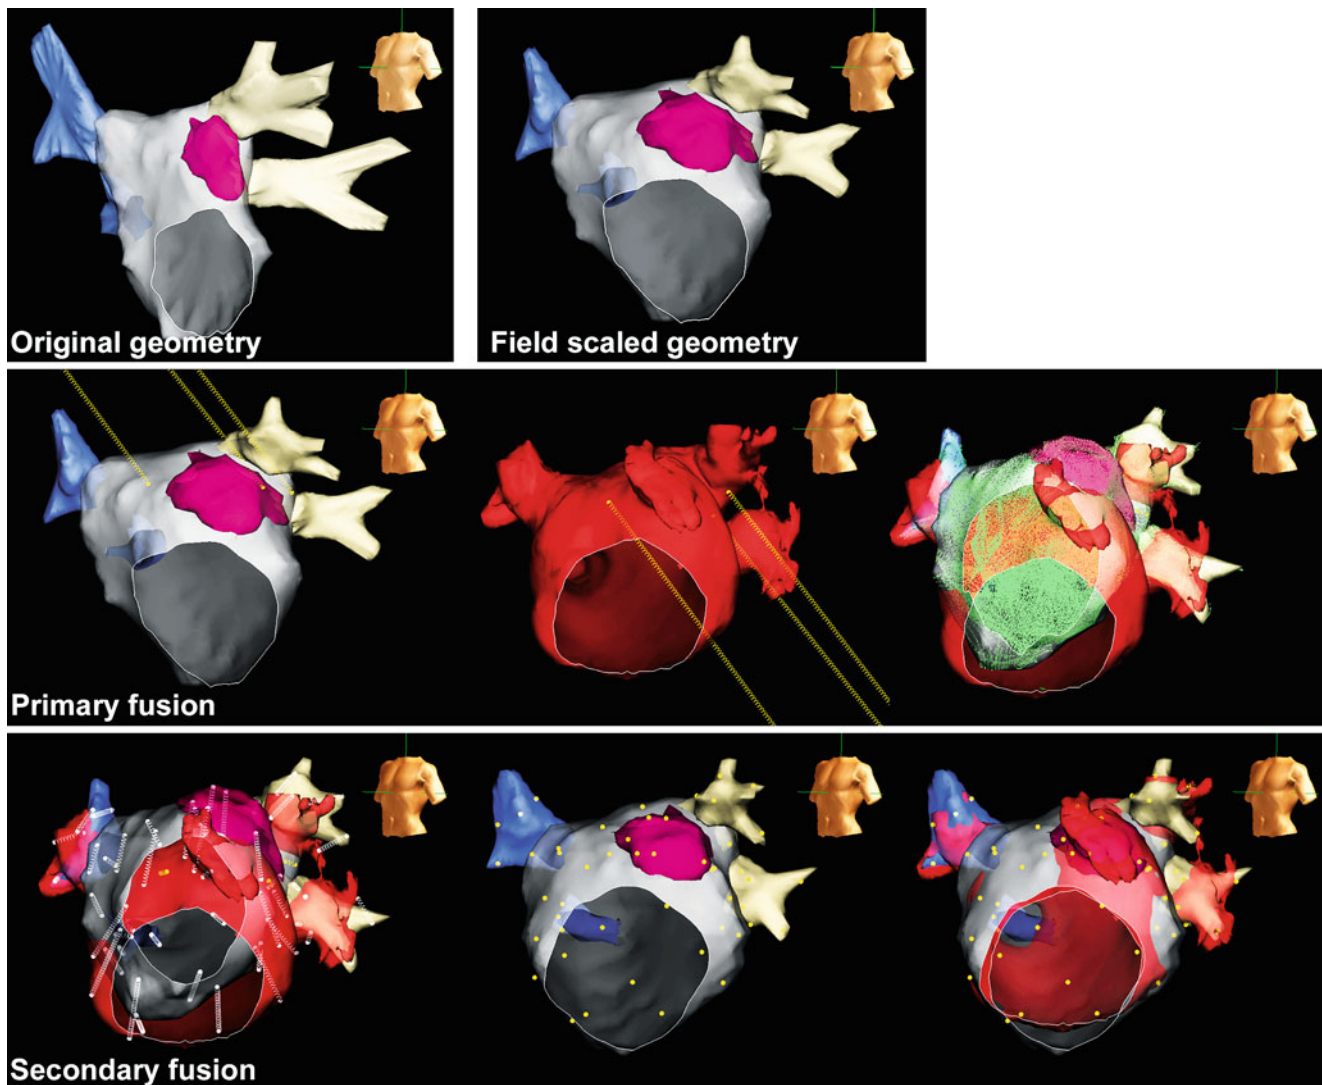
Screenshot series showing progressive improvement in geometry similarity to computed tomography for original geometry, field scaled and primary fused geometry, and secondary fused geometry.
